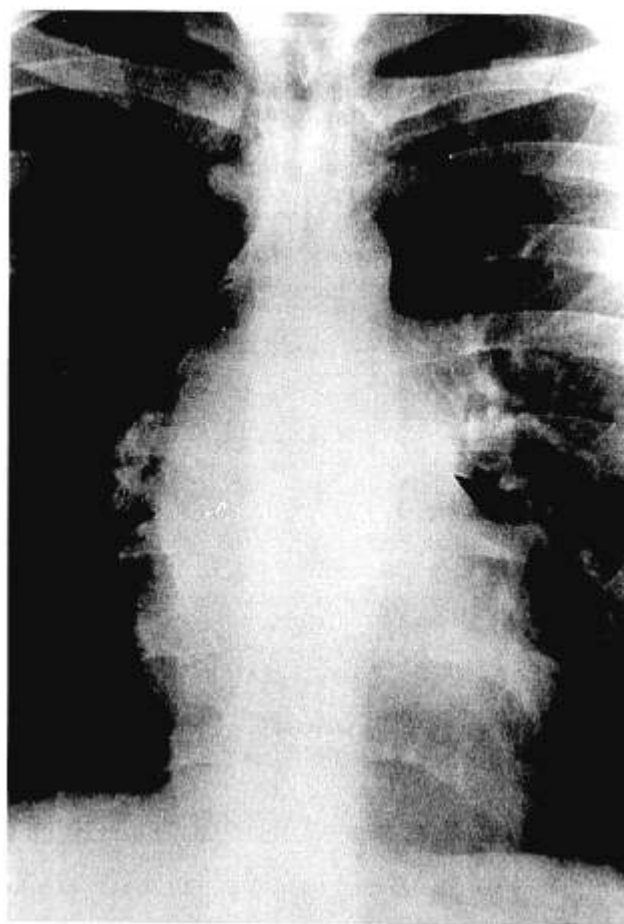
Postero-anterior chest roentgenogram showing a large cyst displacing the main-stem bronchi. Markers show the lateral margins of the cyst. Trachea and main-stem bronchi are outlined.
